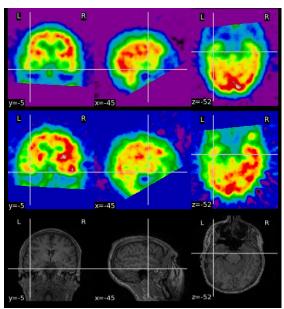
Interictal SPECT, Ictal SPECT and MRI from top to bottom
